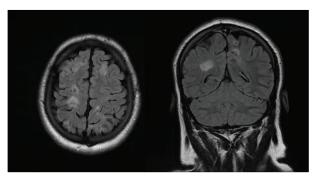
Brain MRI, coronal and axial. Multiple supratentorial lesions
